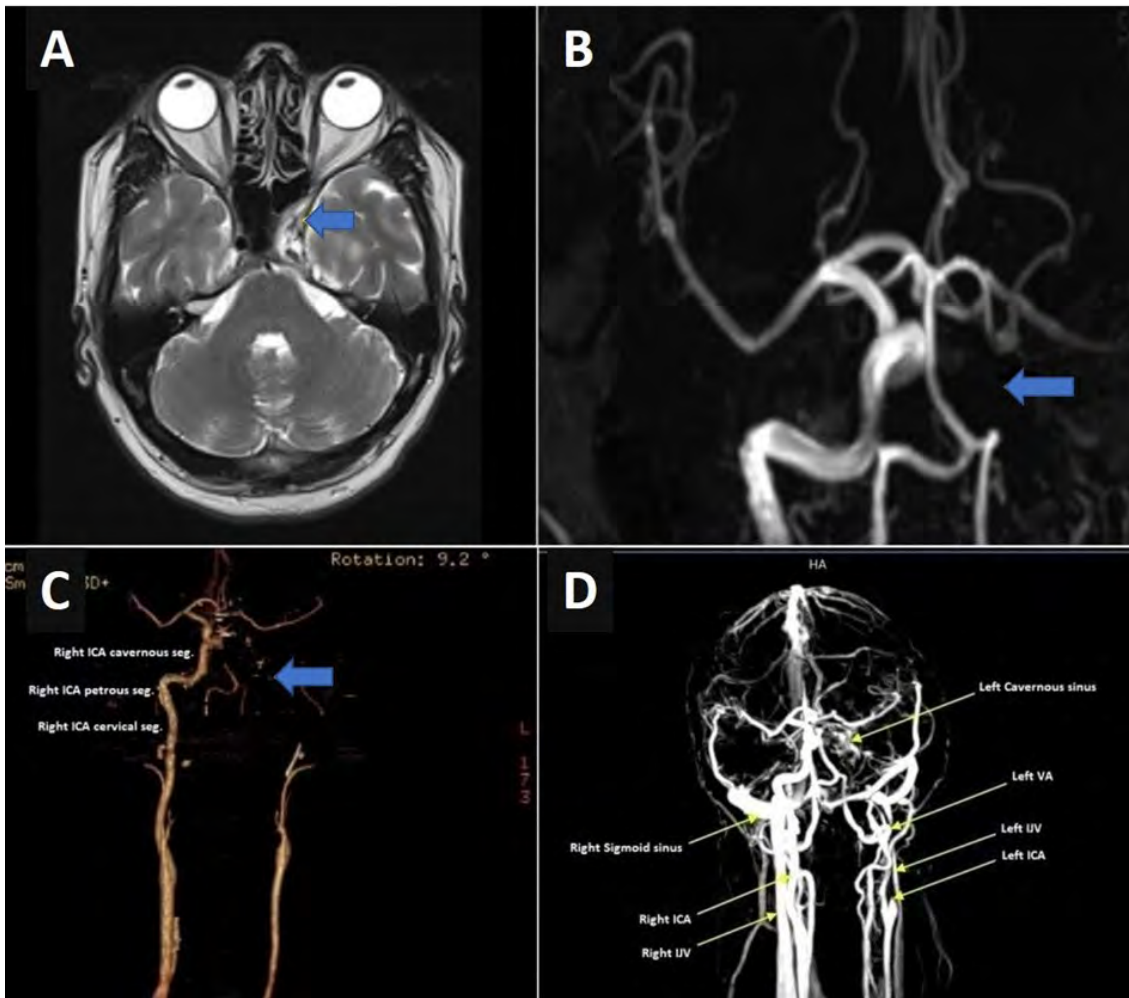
A. Brain MRI with hyperintense heterogeneous lesion observed in the left cavernous sinus on T2 sequences compatible with the cavernous sinus thrombosis (arrow). B. brain MR-angiography of the patient, the left internal carotid artery occlusion was detected (arrow) and it was determined that the left anterior cerebral artery and middle cerebral artery were filling through the anterior communicating artery. C. neck CT-angiography revealed left internal carotid artery thrombosed throughout the entire tracing, starting from the proximal part, and no flow was observed (arrow). D. brain MR-venography, a severe decrease in calibrations was detected depending on the partial thrombosis of the left internal jugular vein, sigmoid sinus and transverse sinuses.
